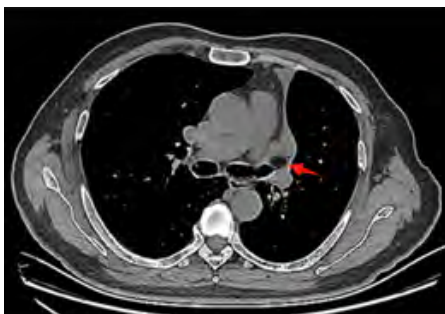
Chest CT scan shows 1.6×1.1cm intraluminal hypodense nodule (arrow) of the left upper lobe bronchus with -123HU (Hounsfield unit) values, simultaneously accompany distal atelectasis.
